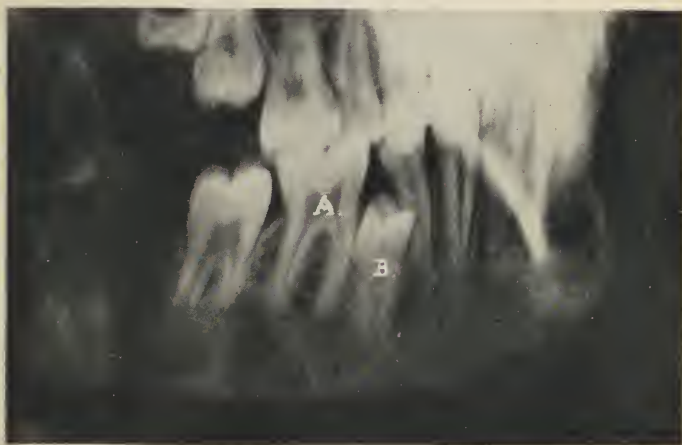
X-RAY PICTURE OF THE TEETH OF A CHILD TWELVE YEARS OLD
